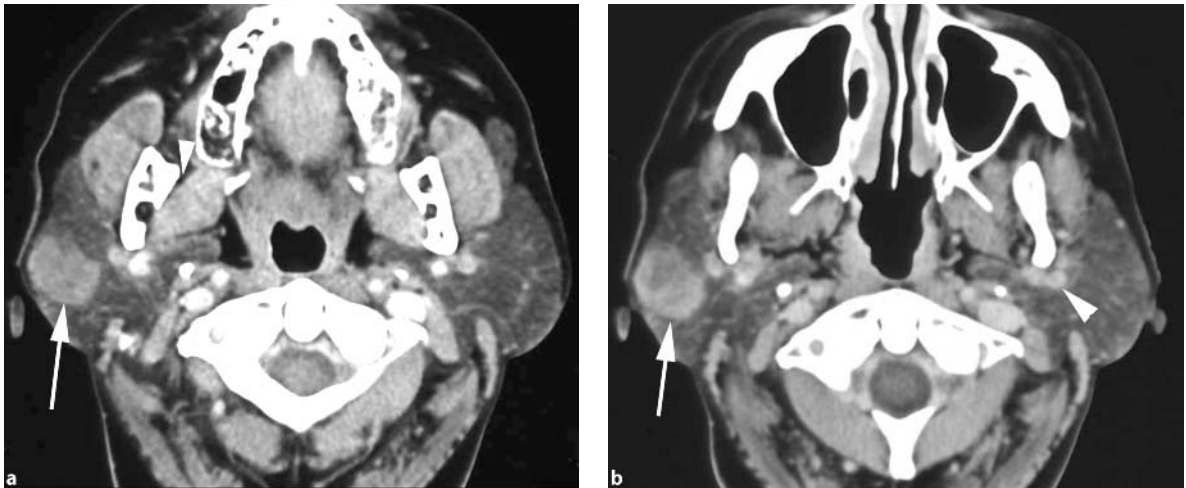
Pleomorphic adenoma. CT showing gradual enhancement after injection of contrast. a Initial axial image. This image was taken immediately after the injection of contrast. The tumor (*arrow*) can barely be seen in the superficial parotid gland. Position of the lingual nerve (*arrowhead*). b Delayed image. After several minutes there is gradual enhancement of the tumor (*arrow*). This is typical of a pleomorphic adenoma. Retromandibular vein (*arrowhead*)
